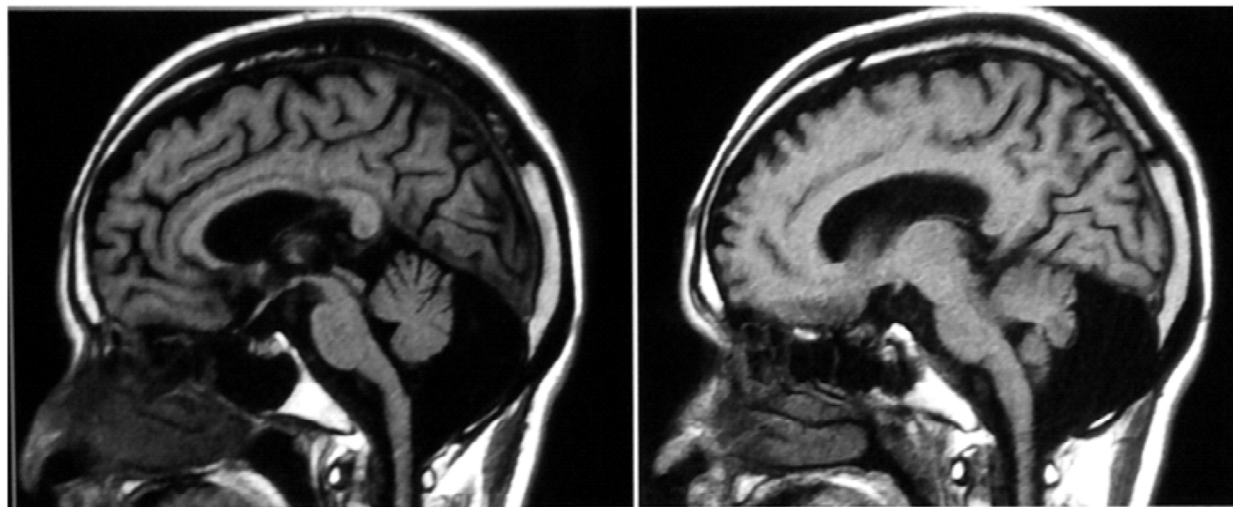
MRI Brain showing Humming Bird sign in PSP
